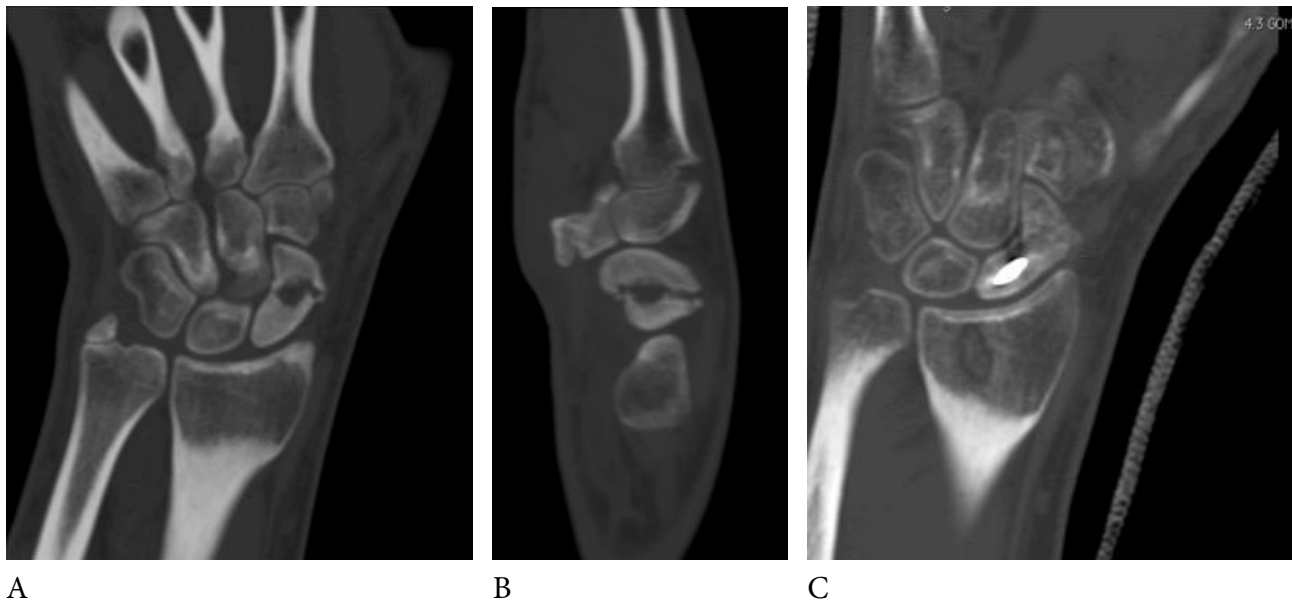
Patient of 19 years with pseudoarthrosis of the scaphoid body. A, B: CT scan of pseudoarthrosis of the scaphoid body with humpback deformity; C: eight-week CT scan shows the healing of pseudoarthrosis.
